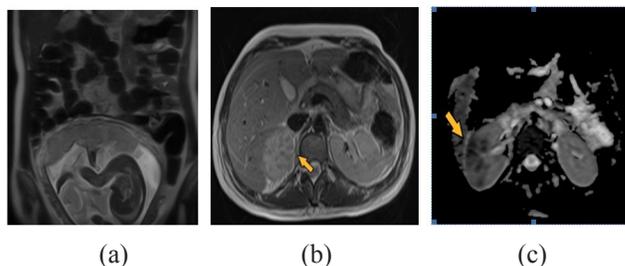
MRI of a pregnant woman (21-22 weeks): a) - T2-WI in the coronal plane, the uterus is enlarged according to the period of gestation, a single fetus in the cephalic presentation in the uterine cavity; b) MRU: thickening of the parenchyma with apostems in the cortical layer (arrows), c) DWI and ADC: foci of diffusion limitation correspond to multiple apostems (arrows).
